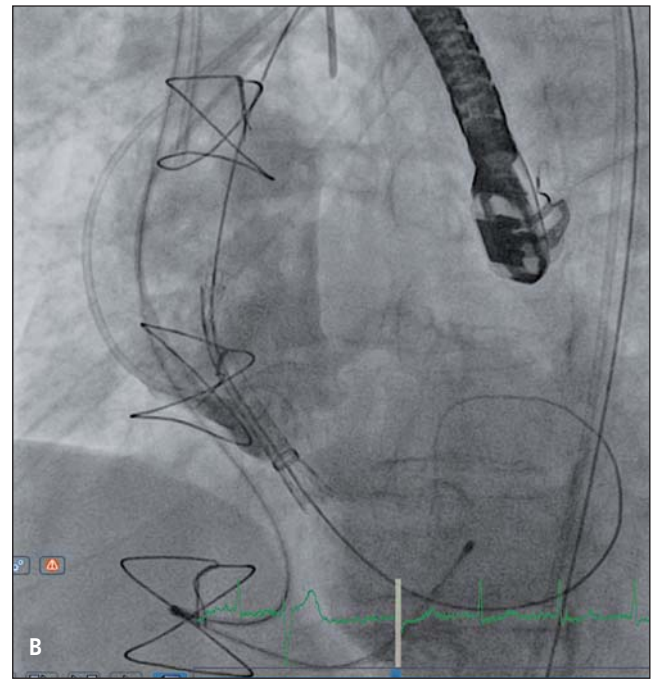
Valve-in-valve procedures with Core Valve and Evolut R. Fluoroscopic images of Transcatheter valve-in-valve implantation – CoreValve 23 (Medtronic) in Freestyle aortic root bioprosthesis (Medtronic): (A) Aortic root with transesophageal echocardiography probe. (B) Pre-implantation. (C) Fluoroscopic view of deployed 23 mm CoreValve.
